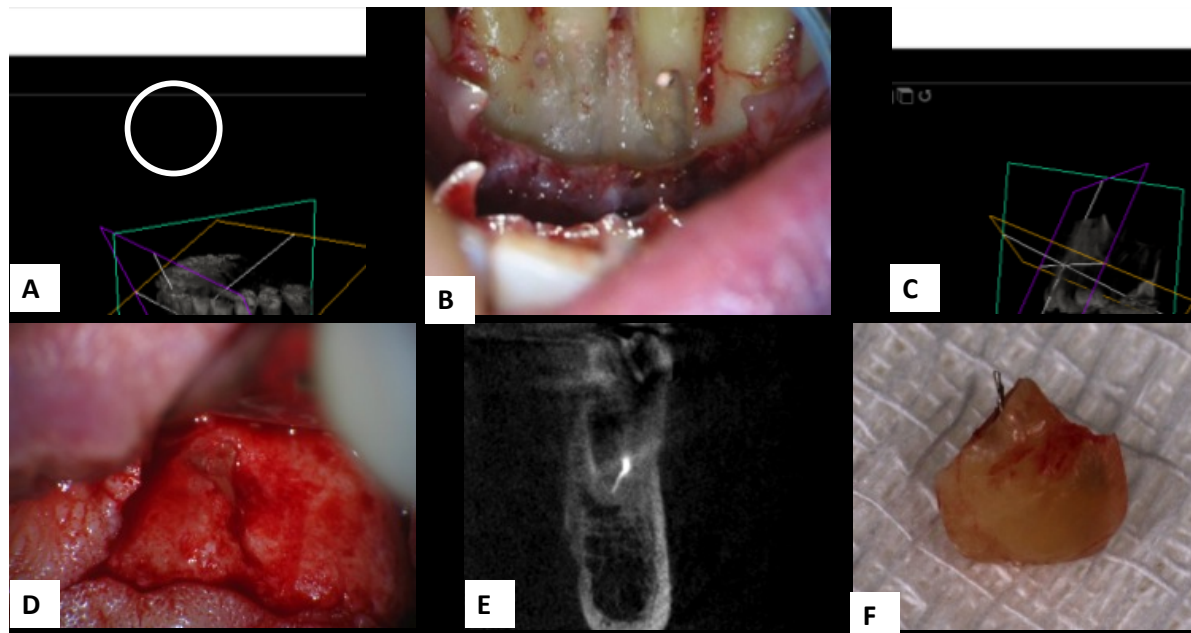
CBCT Images representing the "other" category. The CBCT and clinical images of #25. (A-B) All evaluators correctly assessed there was no hard tissue separating the canal space and gingival tissue. (C-D) All evaluators were correct in answering the same question for #10. (E-F) Two of the 3 evaluators correctly identified that the fractured instrument was in the ML canal of #30. The least experienced evaluator correctly answered that it was in a mesial canal, but was unable to identify buccal or lingual.
